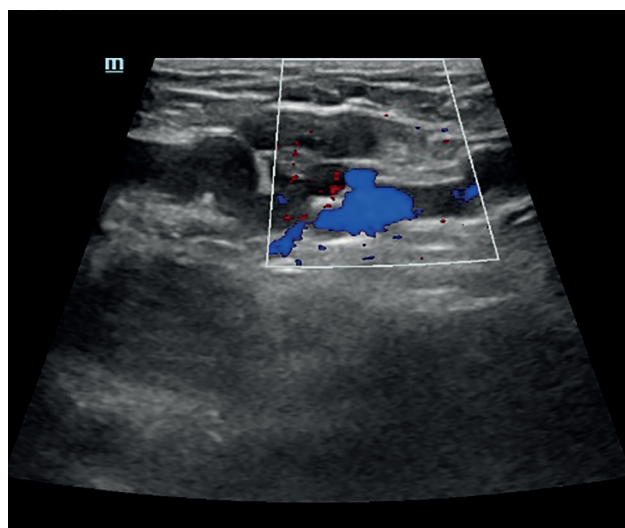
Venous flow on Doppler.
